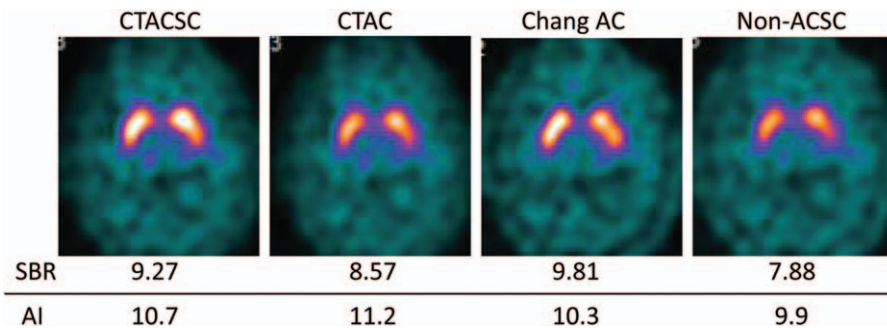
I-123 FP-CIT SPECT images of a 26-year-old male with ET. ET = essential tremor, FP-CIT = N- ω -fluoropropyl-2 β -carbomethoxy-3 β -(4-I-123 iodophenyl)nortropane, SPECT = single-photon emission computed tomography.
